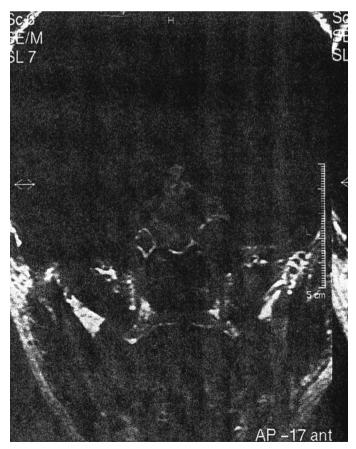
MRI before neurosurgery in the patient with primary pituitary lymphoma (20).
